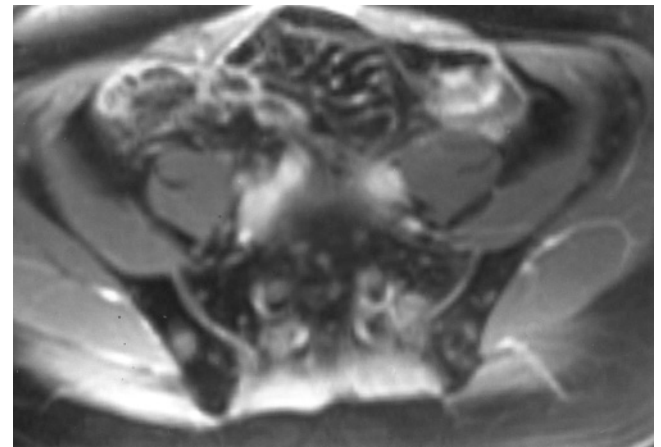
Bone metastases. Two-minute gadolinium-enhanced T1-weighted fat-suppressed SGE image demonstrates multiple rounded enhancing bone metastases that are clearly defined in a background of suppressed fatty marrow.
